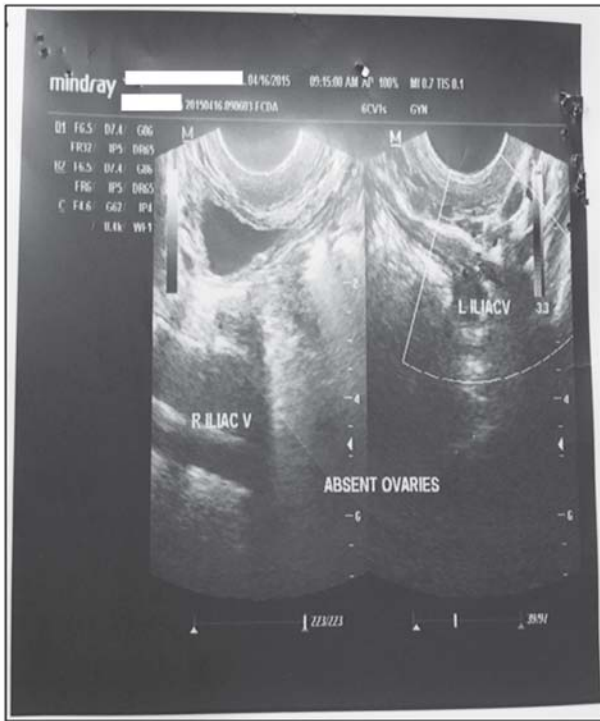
Transvaginal ultrasound image of absent bilateral ovaries.
